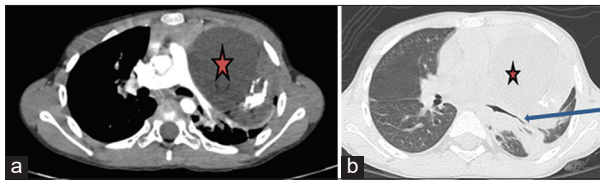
Contrast-enhanced computed tomography chest showing (a) well-defined cystic anterior mediastinal mass with narrowing of left main pulmonary artery. (b) Large anterior mediastinal mass (represented as star) with narrowing of left main bronchus (represented as arrow)
